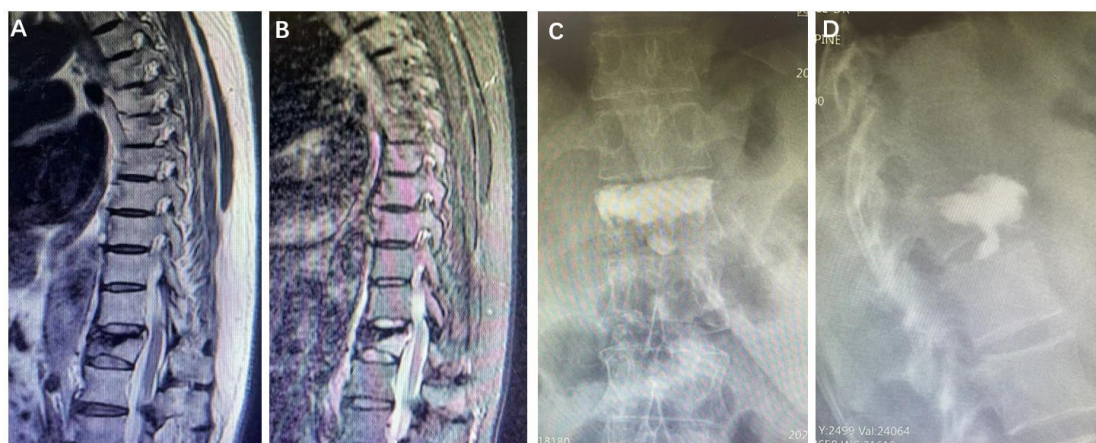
Cement migration into the intervertebral disc following vertebral augmentation in a 63-year-old female with an osteoporotic L2 compression fracture. (A, B) Preoperative sagittal magnetic resonance imaging demonstrating the acute L2 fracture. (C, D) Postoperative anteroposterior and lateral radiographs showing cement migration across the endplate into the adjacent L2–L3 intervertebral disc space.
